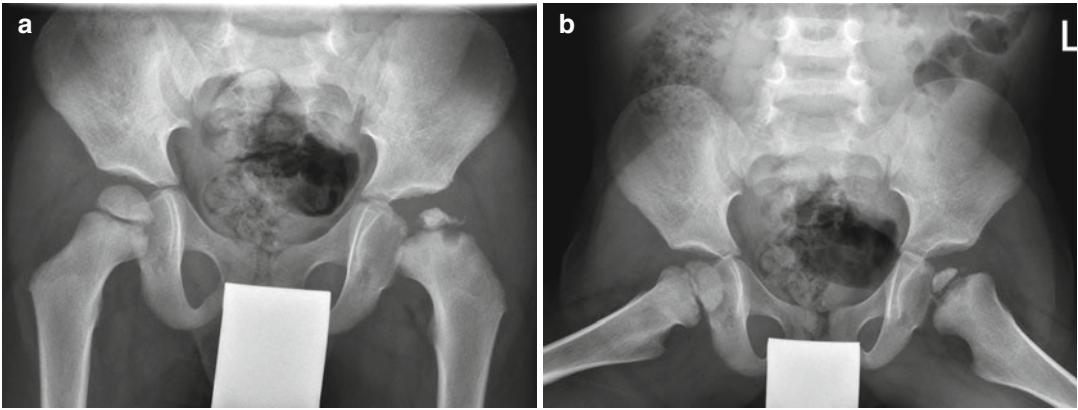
Radiographs of a 5-year-old boy with Perthes' disease as seen on the AP (a) and frog lateral (b) views; note the epiphyseal collapse, sclerosis, and metaphyseal cysts
